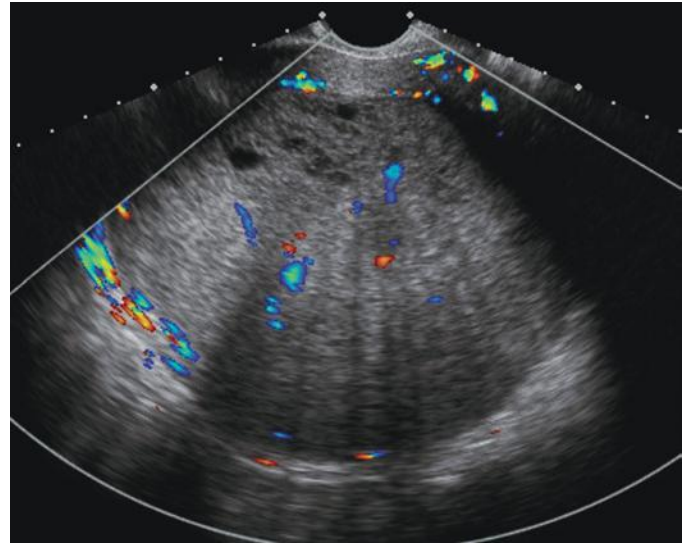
Large relatively echogenic leiomyoma demonstrating small anechoic rounded areas of cystic change anteriorly as well as “venetian blind” shadowing. Both of these features are quite similar to ultrasound findings of adenomyosis.
